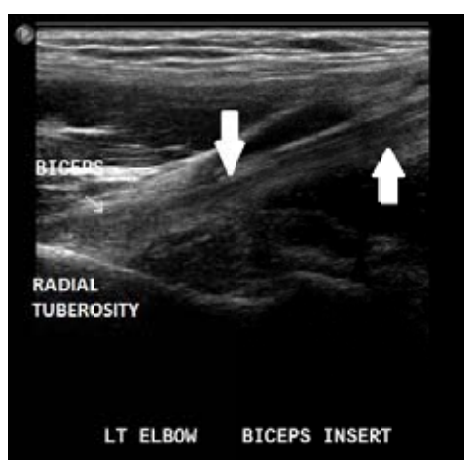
Ultrasound showing a normal distal biceps tendon inserting at the radial tuberosity
